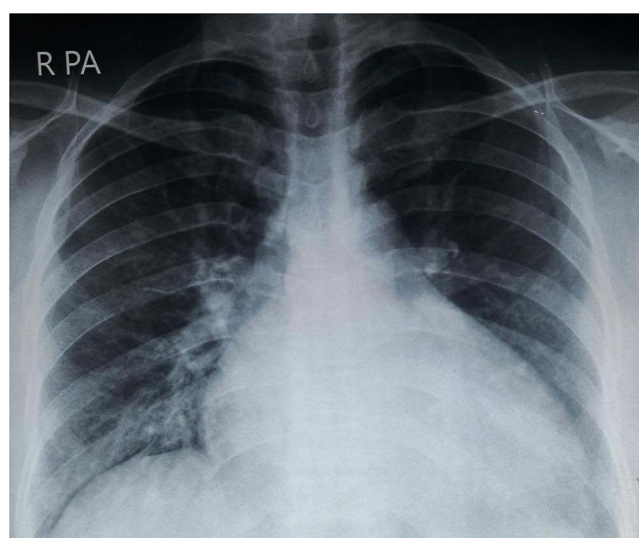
Chest Xray PA (initial presentation) demonstrating cardiomegaly with increased pulmonary vascular markings with left-sided pleural effusion (with R = right side and PA = postero-anterior view).
